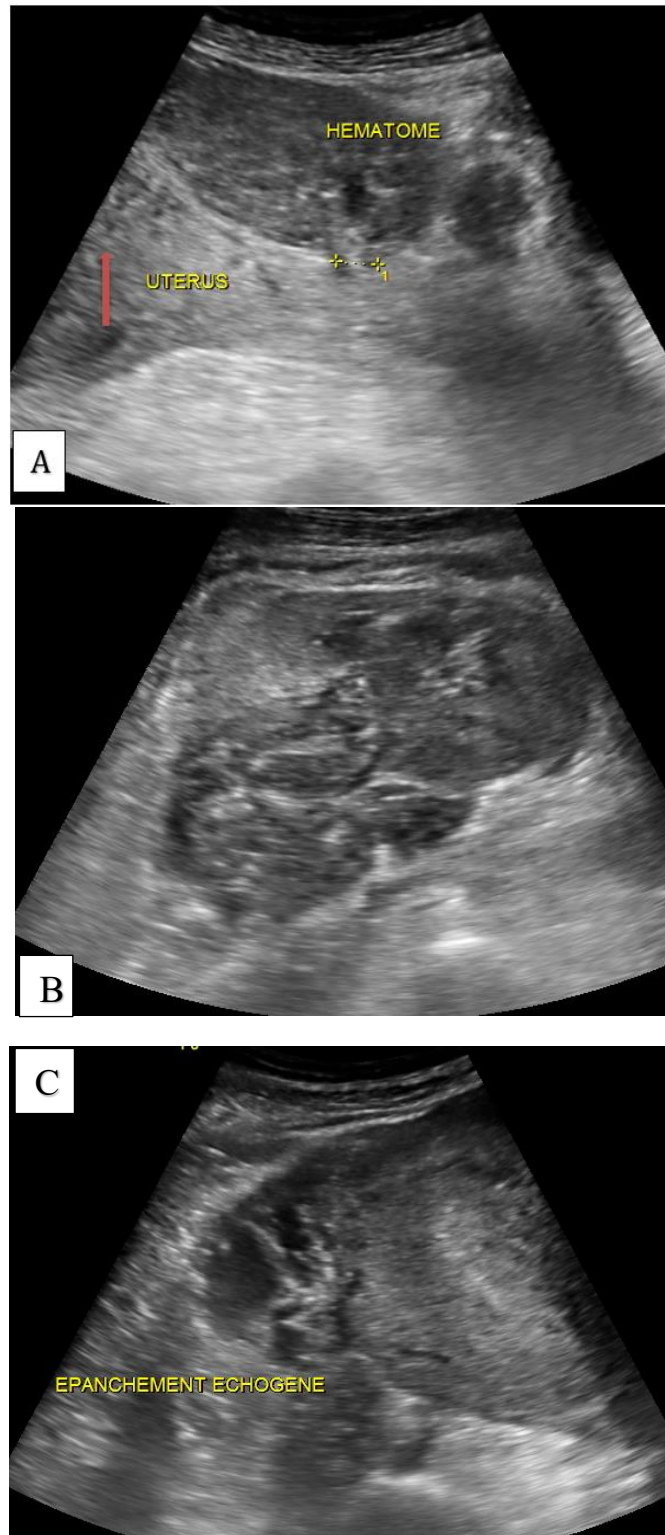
Pelvic ultrasound showing a 9 mm defect (arrow) in the anterior uterine wall (A), a large periuterine pelvic hematoma (B) and hemoperitoneum (C)
